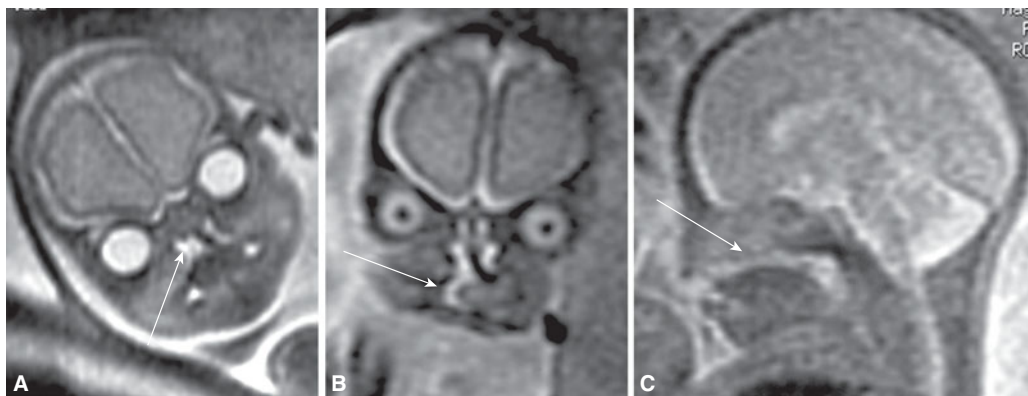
Magnetic resonance imaging (MRI) demonstrating a fetal facial cleft. (A), (B) Coronal sections. (C) Median section demonstrating the central absence of the posterior palate. (Reproduced, with permission, from Ghi T, Tani G, Savelli L, Colleoni GG, Pilu G, Bovicelli L. Prenatal imaging of facial clefts by magnetic resonance imaging with emphasis on the posterior palate. *Prenat Diagn.* 2003;23[12]:970-975.)
